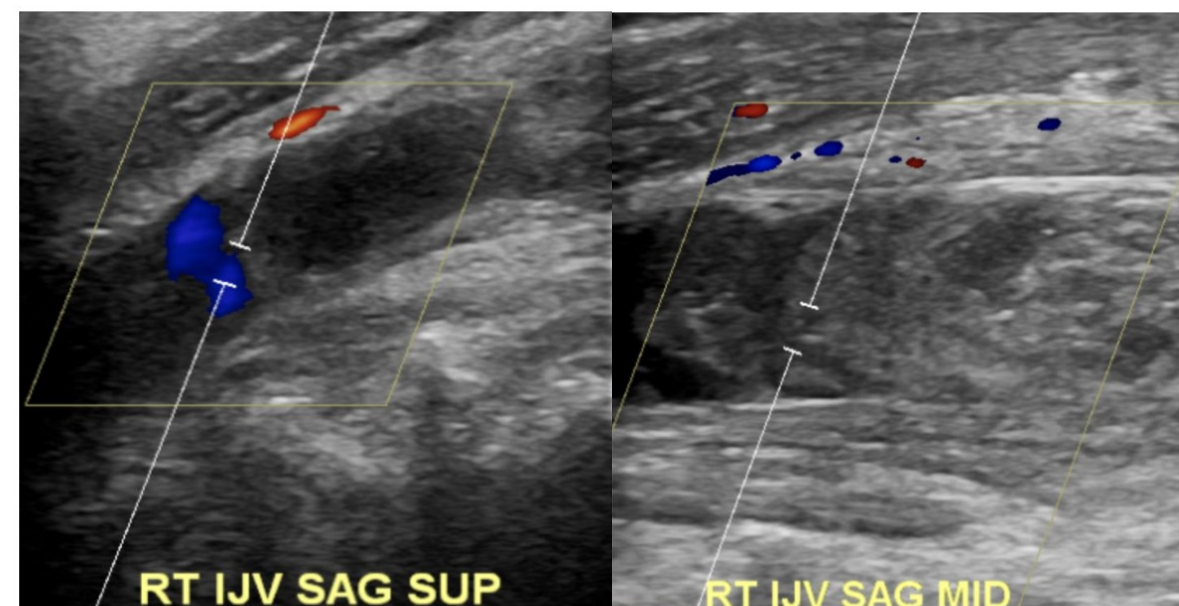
Venous Doppler ultrasound imaging of the right internal jugular vein demonstrating an occlusive thrombus.
